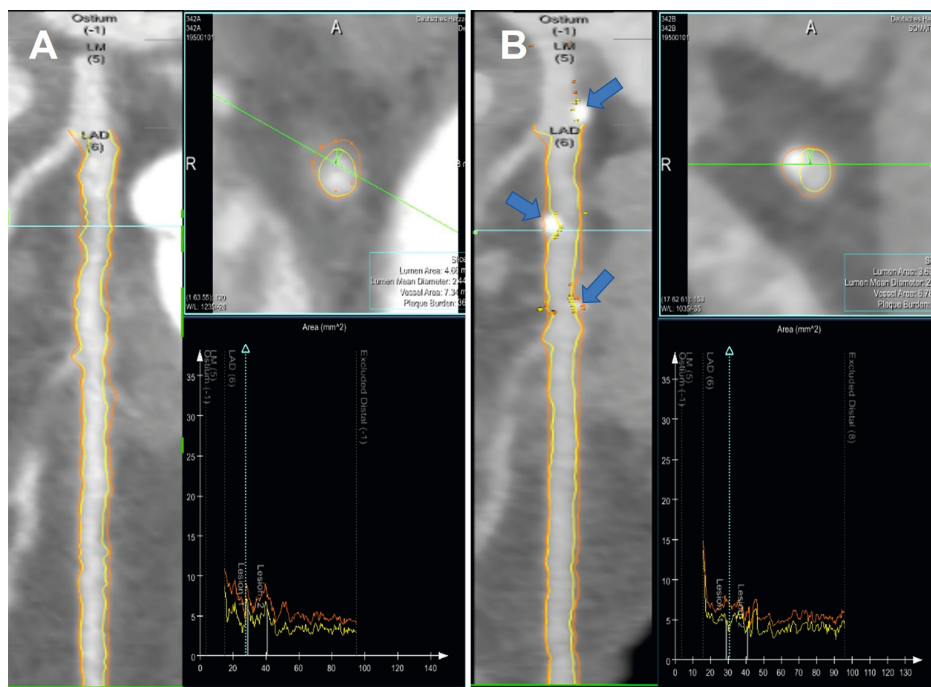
Example, adapted from Weber et al. [5], of a patient who has undergone serial coronary computed tomography angiography (CCTA); the baseline scan is shown in panel A and the follow-up scan is shown in panel B. Plaque delineation is marked by the orange and yellow lines representing the vessel and lumen, respectively. A total of three newly formed calcified plaques are seen in the follow-up scan, as marked by the blue arrows. In this case, the branching of the circumflex (Cx) artery may be used as an anatomical landmark for co-registration by visual analysis. LAD left anterior descending artery, LM left main artery, *mm* millimeters
